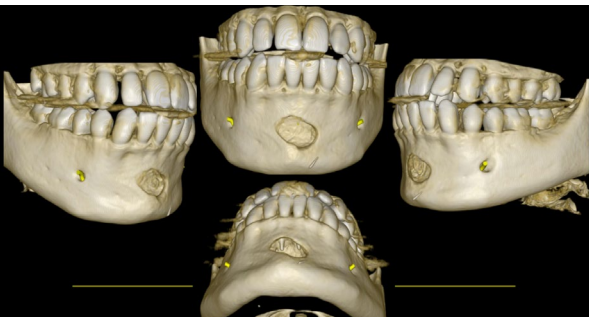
CBCT reconstructed images showing the lesion and dislodged Gutta Percha point
